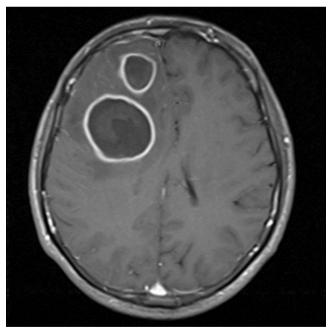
MRI of the head. Patient ZK. Age: 21. Patient's chart no. 25228/2013. Two abscesses in the right frontal lobe, 41 and 26 mm in diameter. Thickened meninges above the area of the abscesses with 2 subdural empyemas of 12 and 10 mm in width and 6 mm thick. Pronounced mass-like effect observed as the compression and shift of the anterior horn of the right lateral ventricle.
